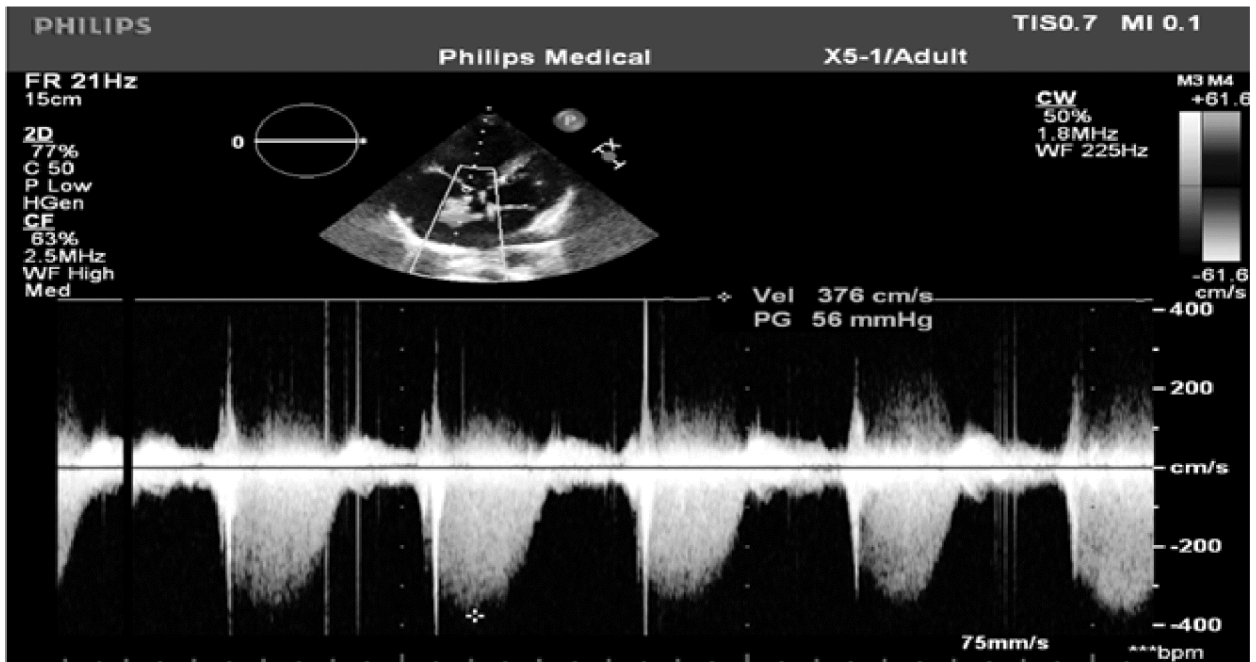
2D echo color doppler image at tricuspid valve showing moderately raised pulmonary artery systolic pressure.
